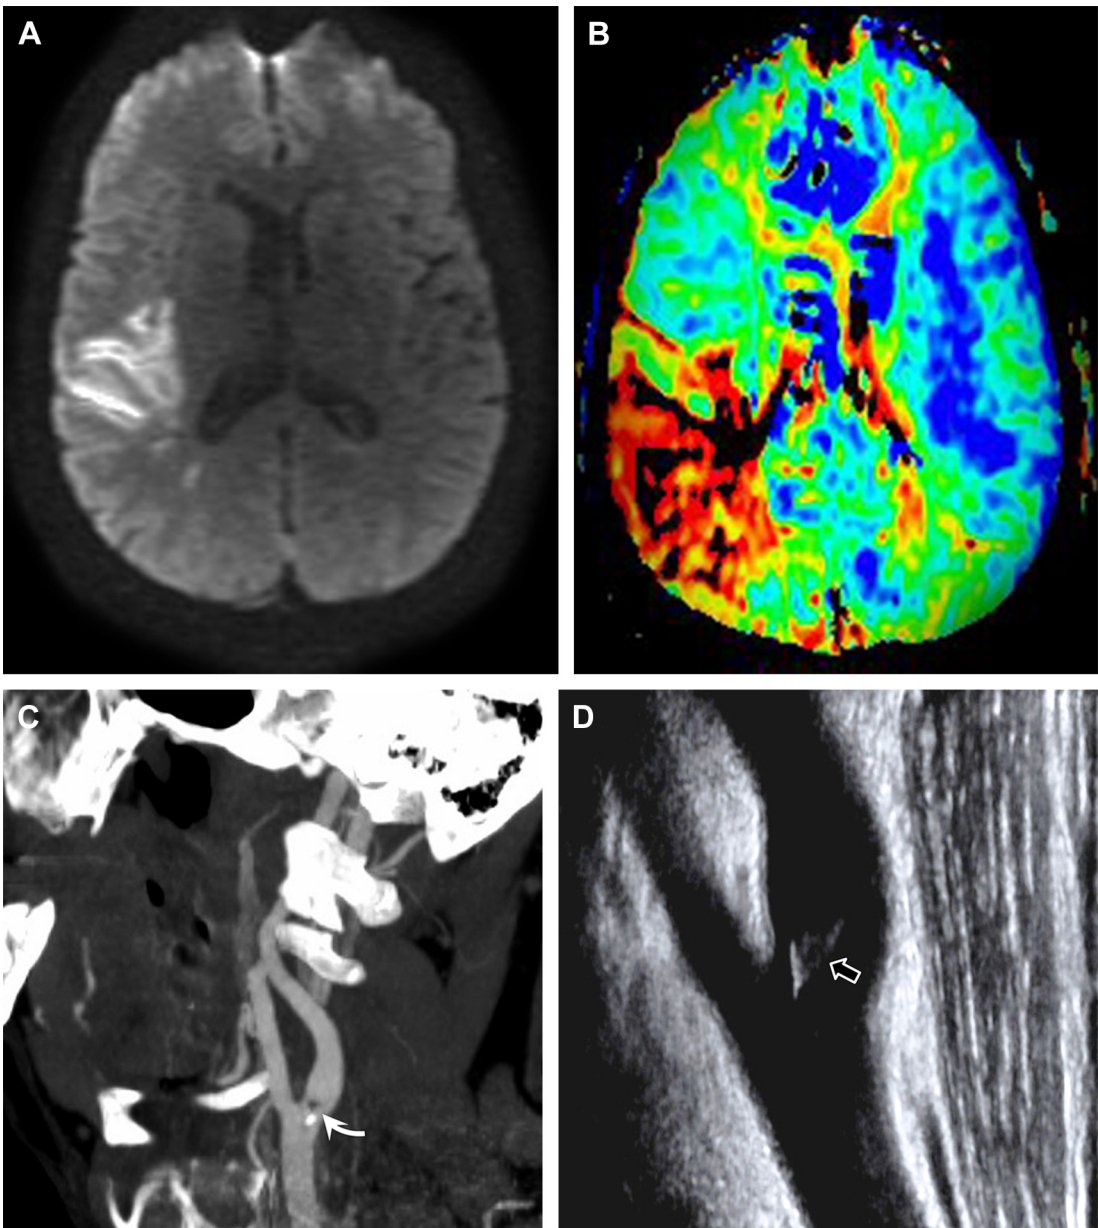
Subtle traumatic dissection with intraluminal thrombus and embolic stroke. (A) Diffusion-weighted and (B) perfusion MR images. This patient presented with a right hemispheric infarct 24 hours following a motor vehicle accident and blunt anterior neck trauma. Note the size of the perfusion deficit is greater than the size of the diffusion-weighted image abnormality, indicating an ischemic penumbra. (C) Sagittal 2D reformatted CTA image reveals a filling defect due to thrombus (*curved arrow*) within the lumen of the ICA without other abnormality. (D) Duplex sonogram confirms the presence of intraluminal clot (*open arrow*) likely due to a subtle traumatic dissection.
